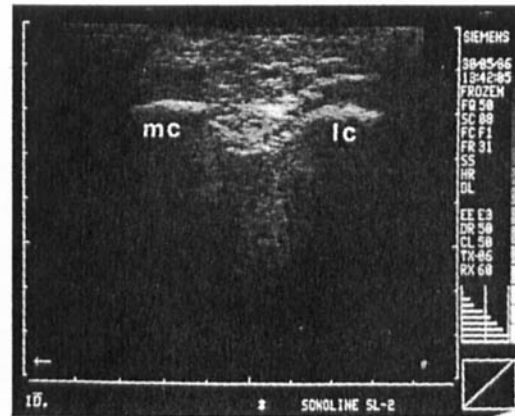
Ultrasound image showing the transverse outline of the posterior femoral condyles (mc – medial, lc – lateral). The tangent of the condyles appears to be horizontal.
